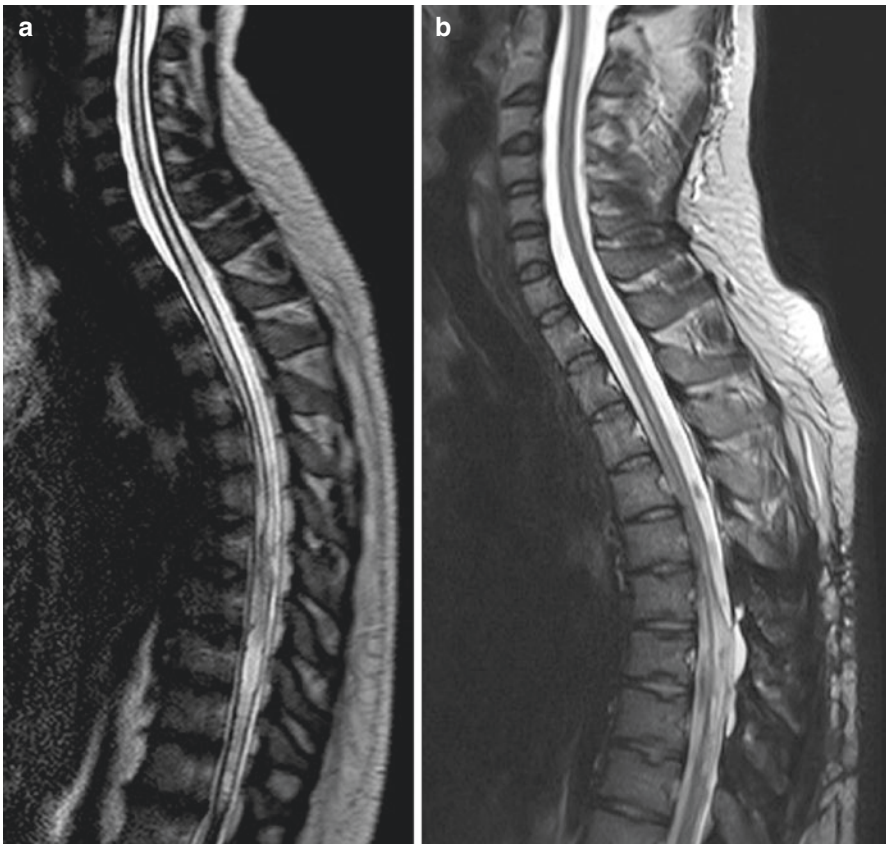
(a) T2-weighted MRI scan of a 29-year-old man with a syrinx C2–Th11 and no history of trauma. At Th7 the cord appears compressed posteriorly and the syrinx caliber changes abruptly. At surgery, a circumscribed arachnopathy was evident at this level obstructing CSF flow and compressing the cord. (b) After arachnolysis and duraplasty at Th7, CSF flow at this level was established and the syrinx decreased
